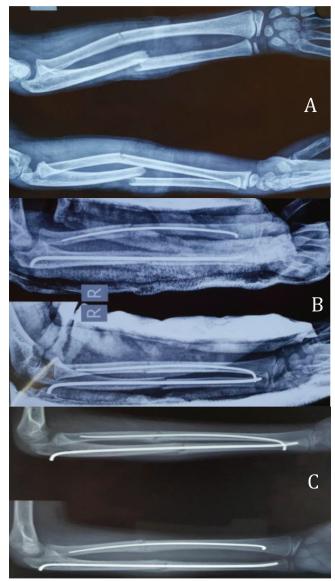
A: Pre Operative X-Ray B: Post Operative X-Ray C: X-Ray At One Month-Showing
